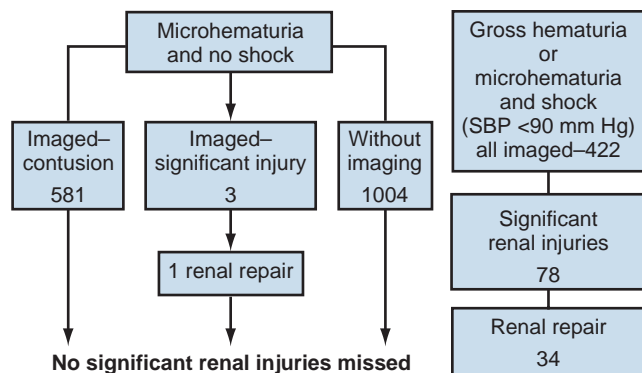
Algorithm demonstrating the results of the authors' study on radiographic assessment of renal injuries. In adults with blunt trauma, imaging studies may be performed selectively. SBP, systolic blood pressure. (From Miller KS, McAninch JW. Radiographic assessment of renal trauma: our 15-year experience. *J Urol* 1995;154:352–5.)
